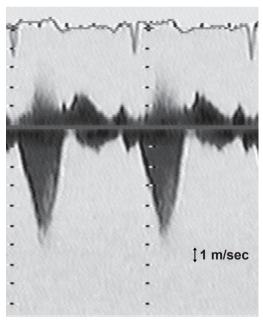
Continuous wave Doppler, characteristic for the dynamic outflow tract obstruction in HOCM patients. Note the late-peaking "daggershaped" appearance of the velocity envelope.
